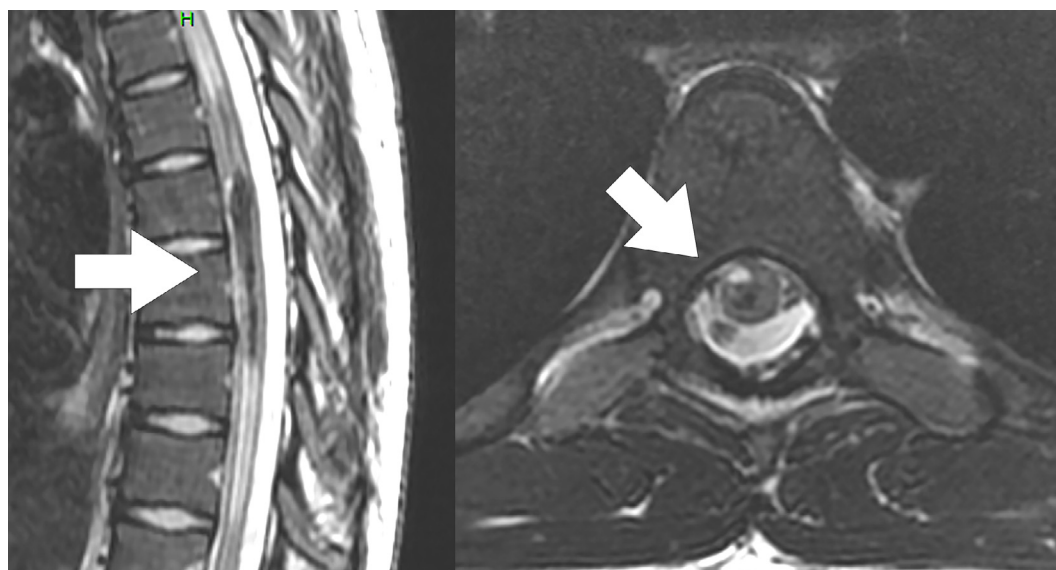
MRI (T2 weighted image, sagittal and axial view). The arrow points towards the intramedullary hypointense lesion the level of the T8-T9 vertebral body. In the axial T2-weighted image the lesion was seen intramedullary, situated mostly on the right ventral side of the spinal cord and also a small T2-hyperintense edge was detected cranially.
